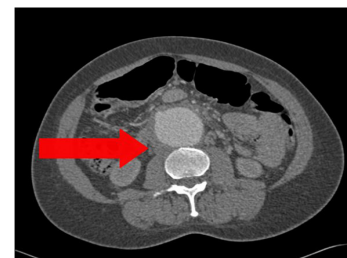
March 2014 CT Scan Abdomen/Pelvis, IV contrast, axial image.
